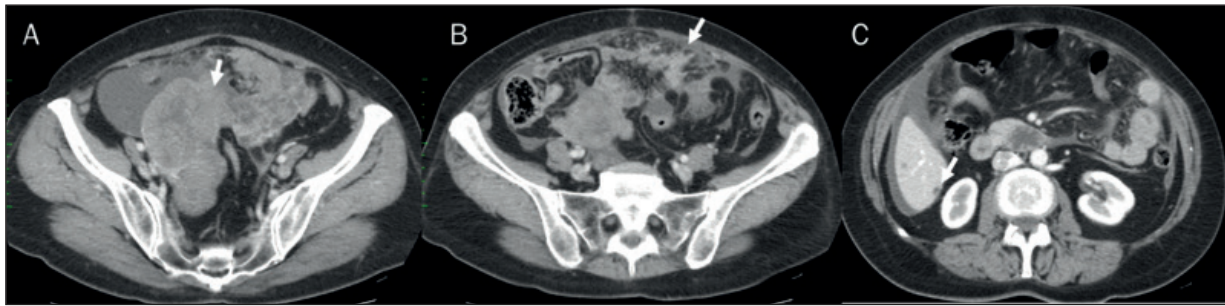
Patient with advanced ovarian cancer assessed on contrast Computed Tomography (CT) study. In A, the arrow shows the primary lesion, in B the arrow shows peritoneal involvement and in C subcapsular hepatic metastasis.
